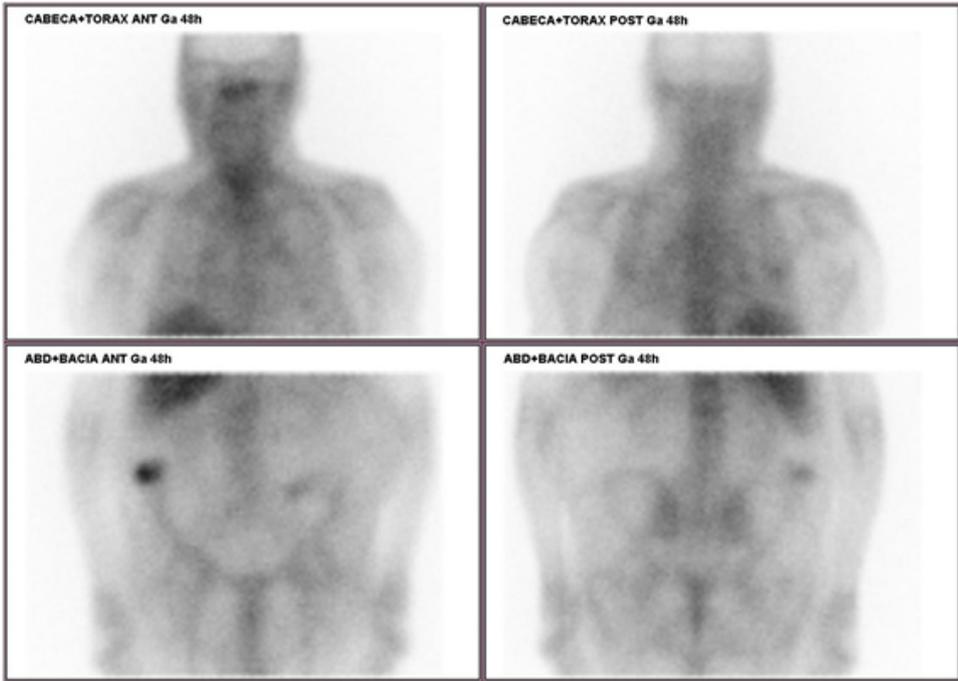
Body scintigraphy with $[^{67}\text{Ga}]$ gallium citrate at 48 hours.
